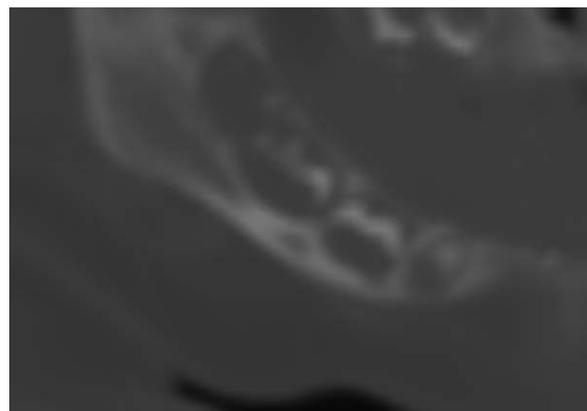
An oblique sagittal reformatted CT image of the lower right quadrant of a 3-month-old child. Note the appearance of the deciduous molars, indicating the occlusal surface is complete. The notation of this stage of attainment compared to that visible in the periapical radiograph (Fig. 3) has possibly corrected the underestimation found in other studies. The notation of the stage of attainment for the permanent molar remains unchanged at C_1 .
